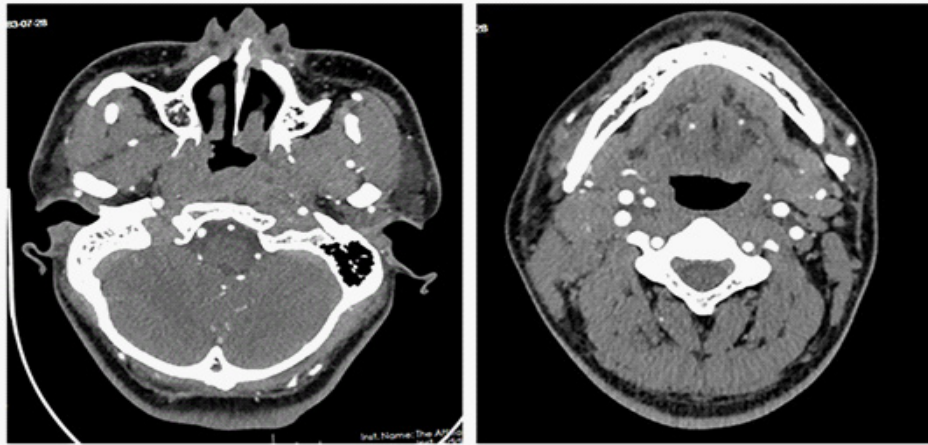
CT image of the patient with the first nasopharyngeal tumor(left) and neck lymph node(right) metastasis on December 31, 2020.
